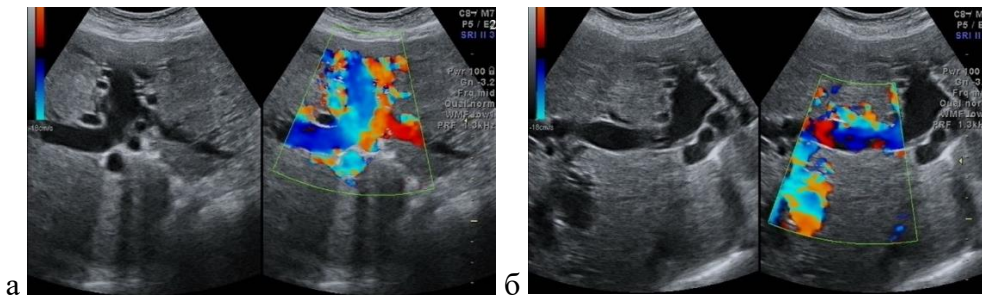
Ultrasound images of the liver in Color Doppler Imaging: a – left branch of the portal vein with multiple AV-shunts; b – right branch of the portal vein with multiple AV-shunts; c – AV-shunts on the liver periphery
